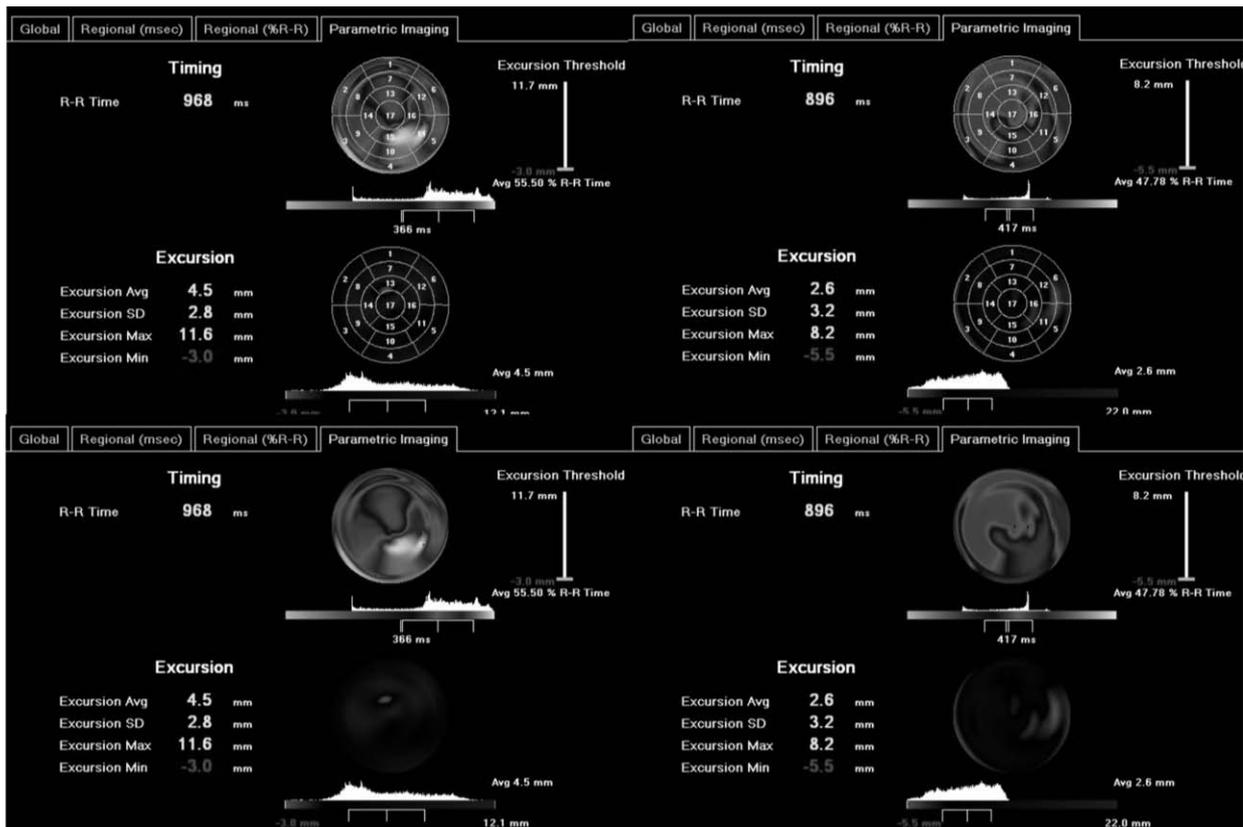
Real-time three-dimensional echocardiography parametric images from a heart failure patient with the standard myocardial segmentations before resynchronization therapy (left upper panel), without segmentation (left lower panel) and after resynchronization therapy with (right upper panel) and without myocardial segmentations. Note the reversal of myocardial activation pattern in the most delayed (yellow-red) postero-lateral and posterior segments to earlier (blue) contraction after therapy. For full color image see the end of this book.
